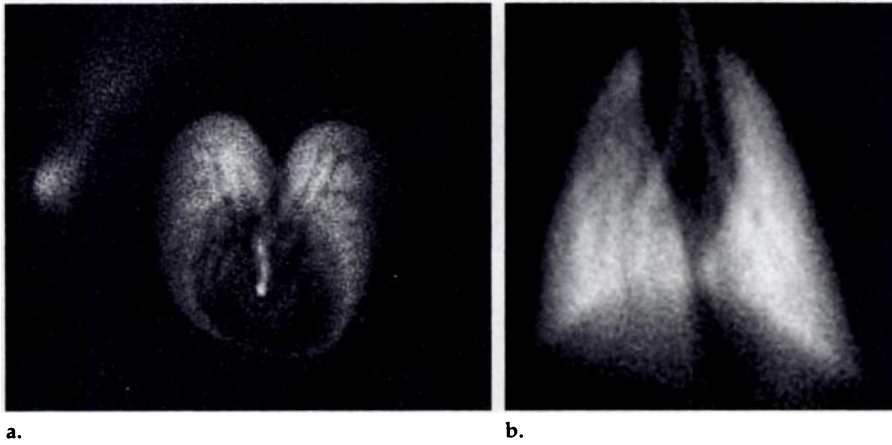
Two-dimensional He-3 MR images were obtained in (a) axial and (b) coronal orientations, with 400 × 400-μm in-plane resolution.
